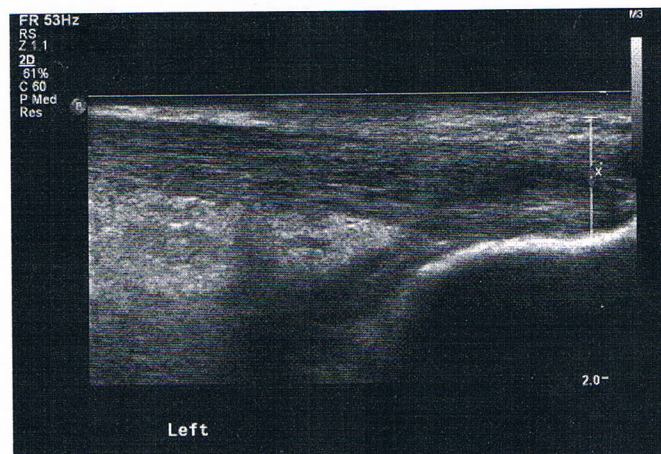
Ultrasound scan showing chronic Achilles tendinopathy with hyperechoic changes indicative of edema within the tendon substance.
